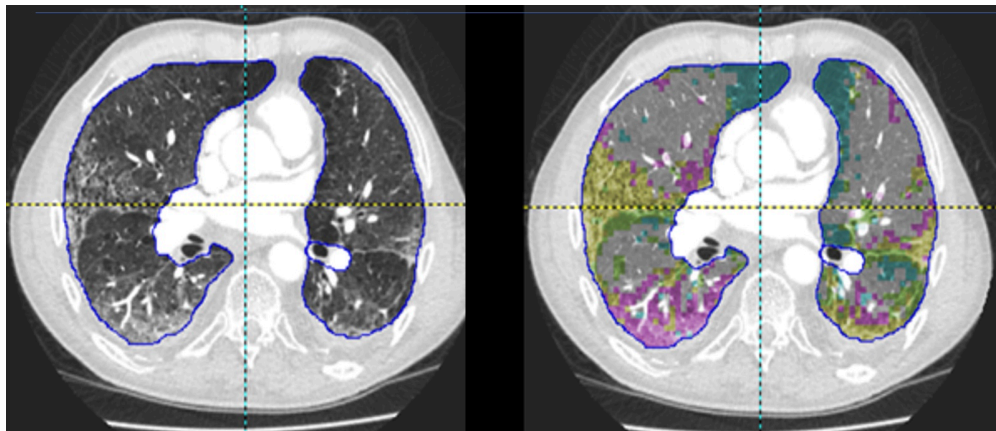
Demonstration of a Quantitative CT approach (adaptive multiple features method), acquired using PASS software. Different lung parenchymal disease patterns are identified and highlighted. Blue - emphysema/low attenuation pattern. Yellow - Fibrotic changes. Pink - Ground glass change.
